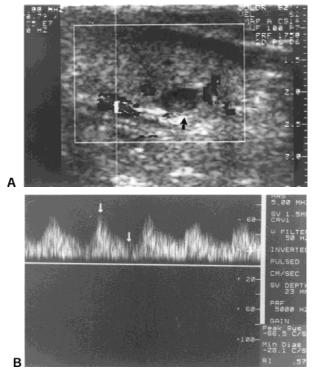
Parathyroid adenoma in left inferior position: (A) color Doppler imaging demonstrates a discontinuous vascular arc around the periphery of the adenoma (arrow); (B) respective increased peak velocity measured in the inferior thyroid artery.
